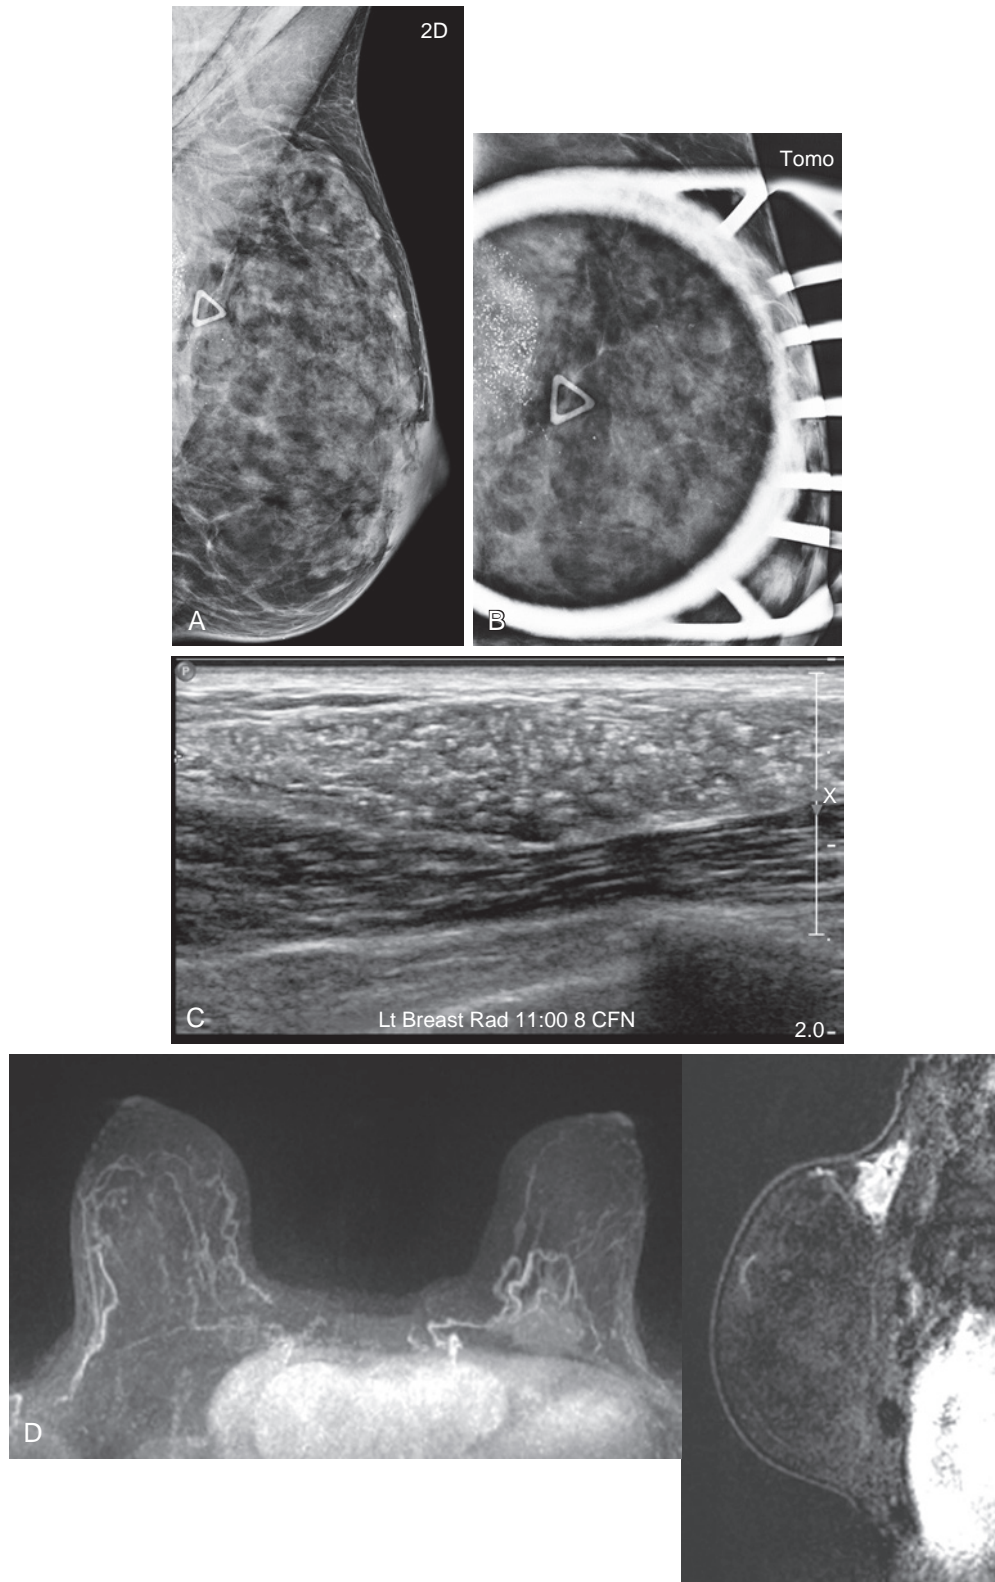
(A) A 55-year-old woman presented with a palpable mass in the posterior left breast. Diagnostic mammogram shows clustered coarse pleomorphic calcifications spanning an area of 3.8 cm. (B) Spot tomosynthesis view shows the calcifications in extremely dense tissue. (C) Ultrasound shows an oval mixed echogenicity mass correlating with the palpable abnormality and mammography findings. Ultrasound biopsy revealed ductal carcinoma in situ (DCIS). (D) Maximum intensity projection and T1-weighted, sagittal, post-contrast subtraction views of MRI show a corresponding irregular mass in the left breast at the 11-o'clock posterior depth, abutting the chest wall with heterogeneous enhancement and delayed washout-type enhancement pattern. Lumpectomy showed DCIS, grade 2 to 3.
